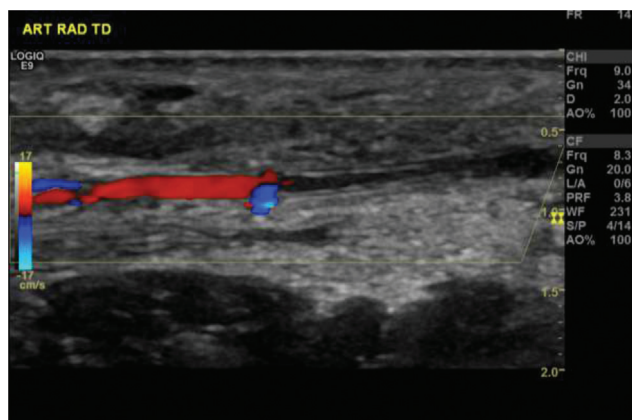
Doppler ultrasonography examination showing an obstructed artery.
